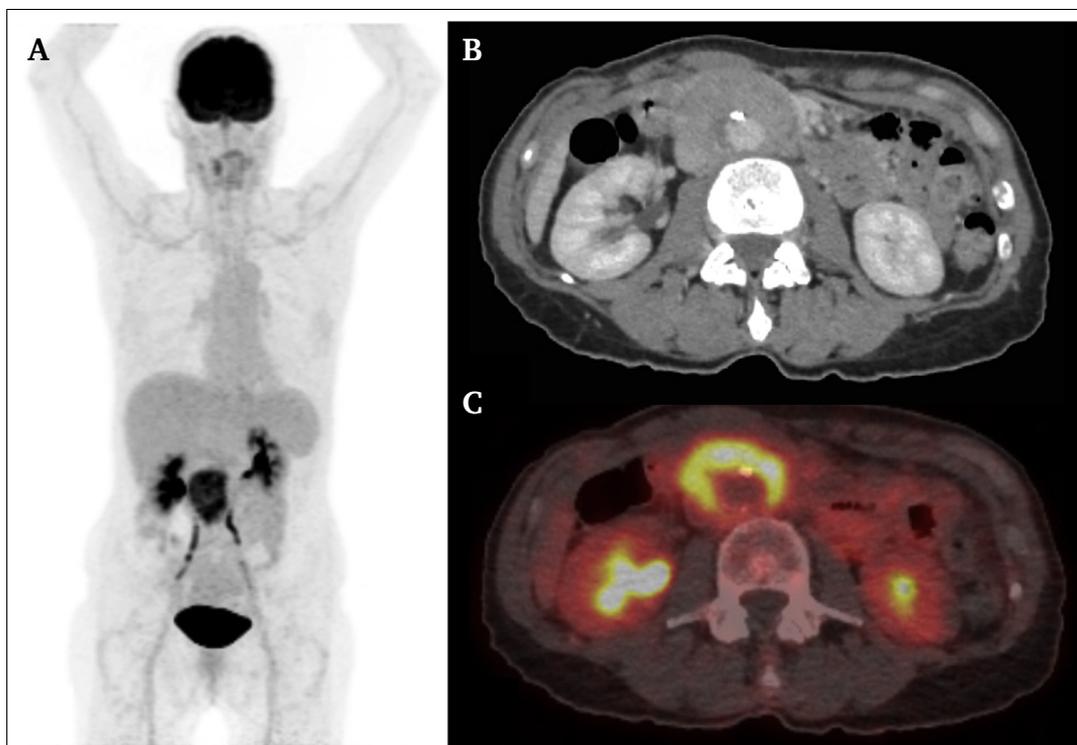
A 65 year old female patient presented with general weakness and abdominal pain. Maximum intensity reconstructions of positron emission tomography (PET) (A) and fused PET/computed tomography (CT) images (C) showed strongly increased ^{18}F -fluorodeoxyglucose (FDG) uptake in the wall of an abdominal aortic aneurysm. Contrast enhanced CT (B) showed profound thickening of the wall of the aneurysm as well as contrast enhancement in the vessel wall. Both readers of PET/CT and contrast enhanced CT rated the examination false positive for an infected aortic aneurysm. However, the final diagnosis was an inflammatory aneurysm caused by Ormond's disease.
